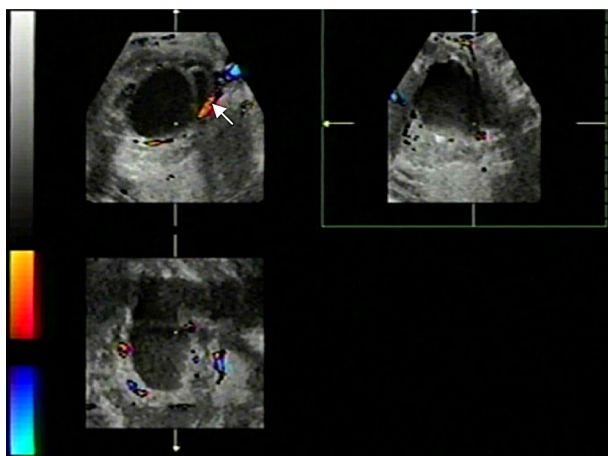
Prenatal fetal three-dimensional (3D) ultrasound (multiplanar orthogonal view) showed a cystic mass behind the bladder in the fetal abdomen (arrow).
